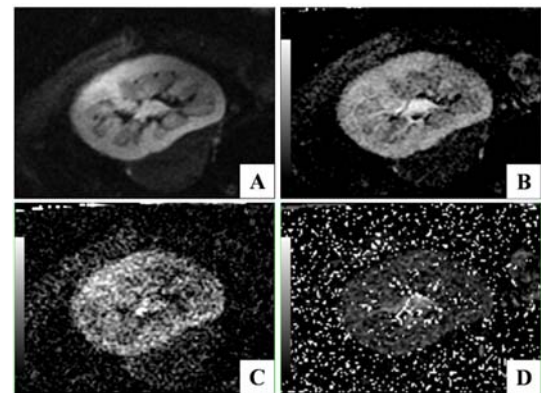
DWI images and parameter maps
